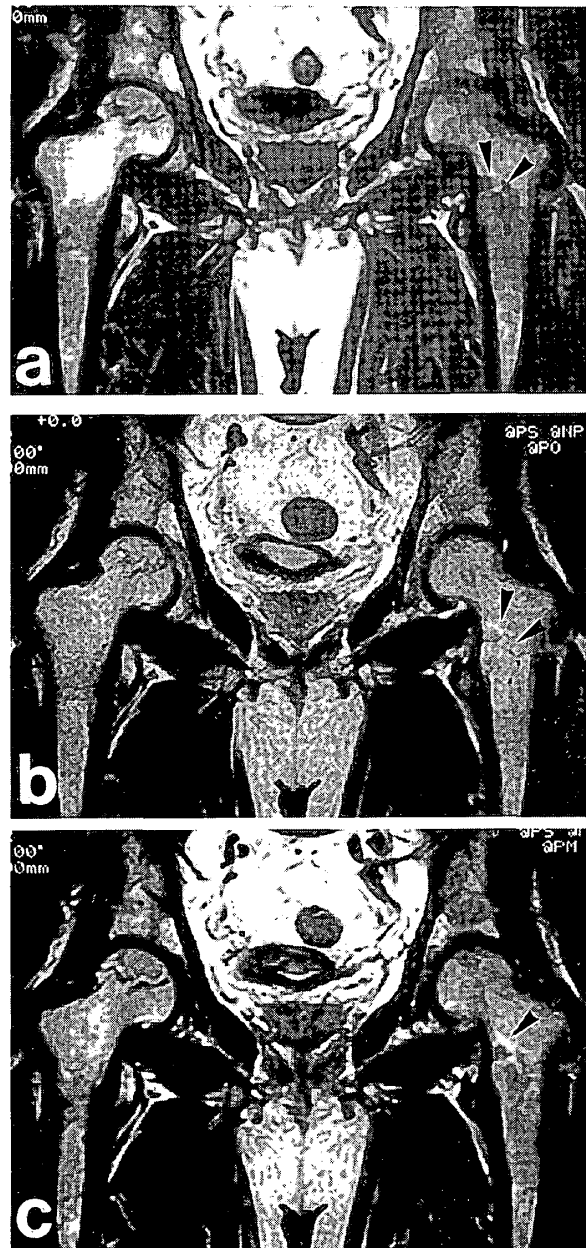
(a) A coronal T1-weighted MR image. A low-signal-intensity lesion in the left femoral head and a band pattern in the right femoral head were recognized. The radiolucent lesion in the metaphysis shown in Fig.2a had low-signal-intensity (arrowhead). (b) A coronal T2-weighted MR image. The lesion in the metaphysis was depicted to have high-signal-intensity (arrowhead). (c) A gadolinium-enhanced MR image. The edge of the metaphyseal lesion was enhanced (arrowhead).
